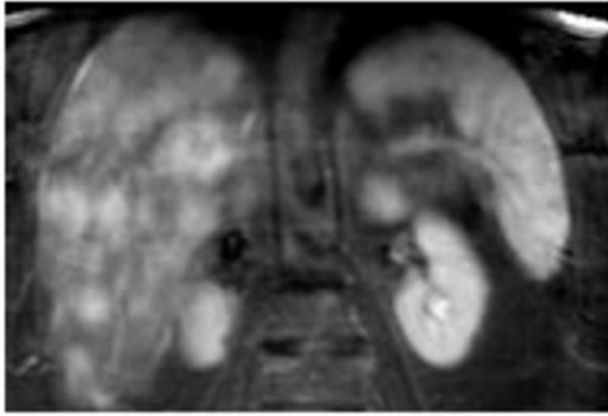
DWIBS images show multiple metastatic lesions with restricted DWI signals
